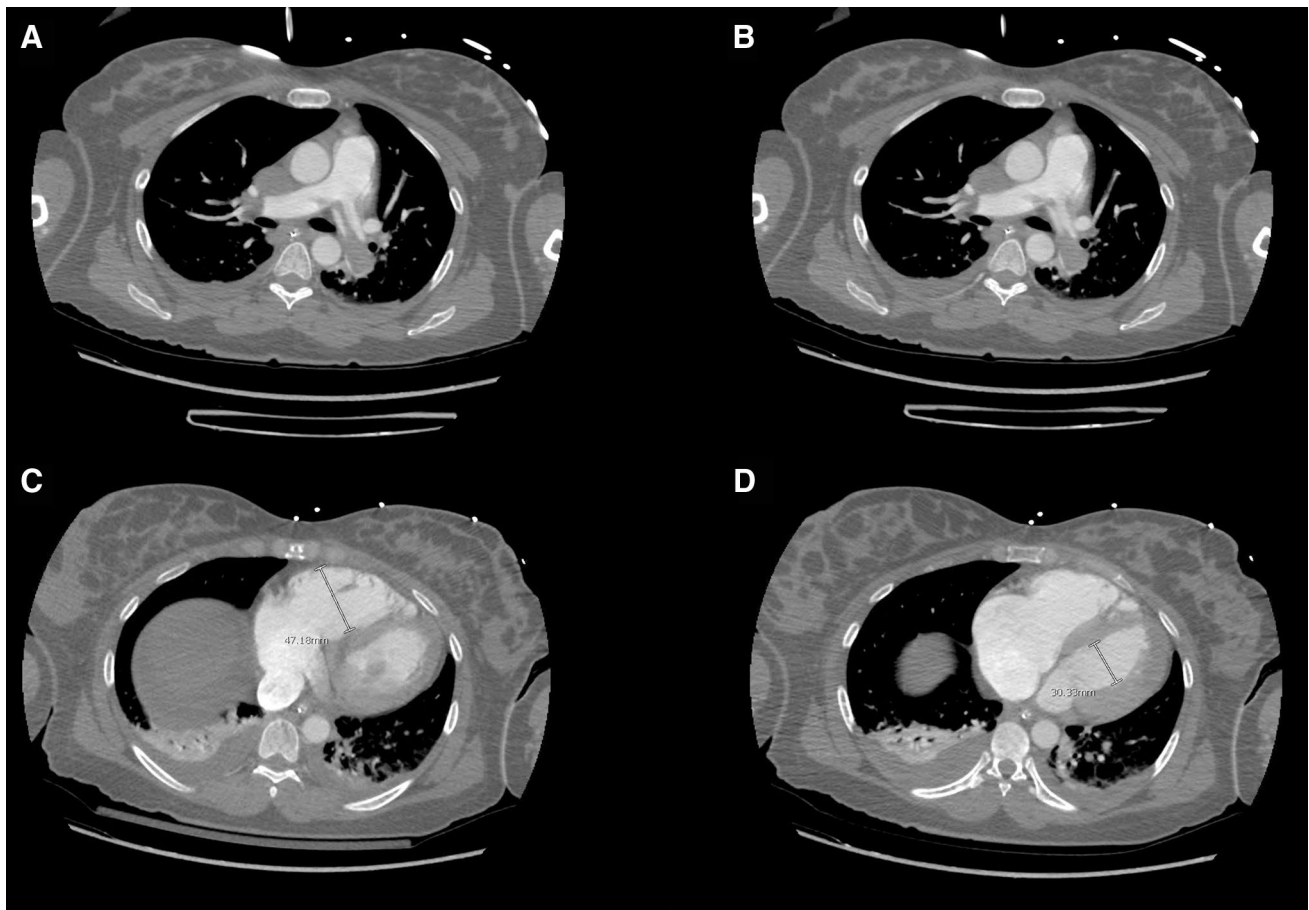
Computed tomographic angiogram of the chest: a saddle embolism, b emboli extending to lobar arteries, c right ventricle strain, right ventricle measuring 47.18 mm, d left ventricle measuring 30.33 mm
